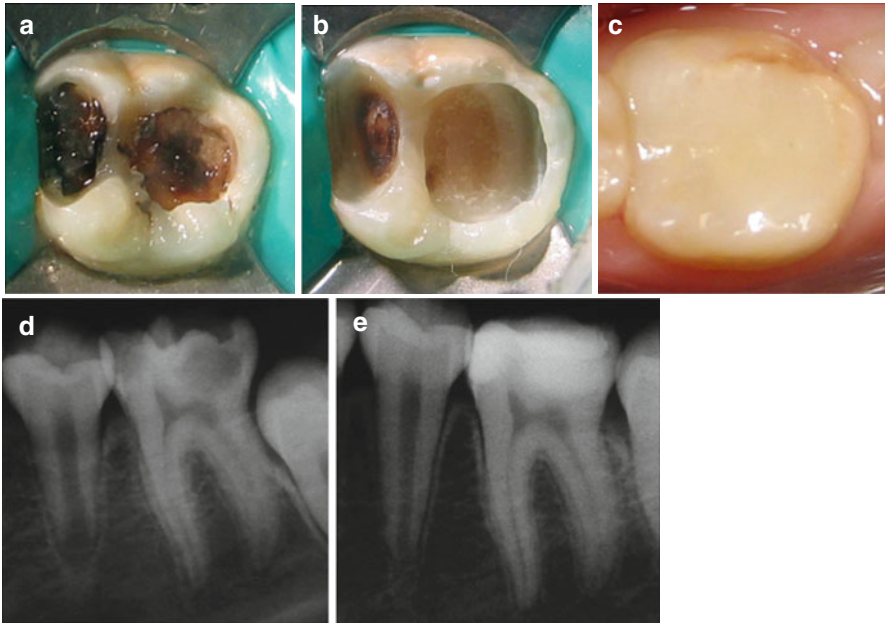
Clinical photographs and radiographs depicting a 1-visit indirect pulp therapy of permanent mandibular left first molar. (a) Tooth with a deep carious lesion with large accumulations of cariogenic biomasses. (b) Clinical photograph showing the cavity preparation (caries was not completely removed at areas close to the pulp), prior to the final restoration. (c) Clinical view after 1-year follow-up. (d) The pretreatment radiograph shows no apical pathosis, but a deep carious lesion. (e) After 1 year, the radiograph shows no apical radiolucency with successful treatment (Reprinted from Orhan et al. [51]; with permission)
